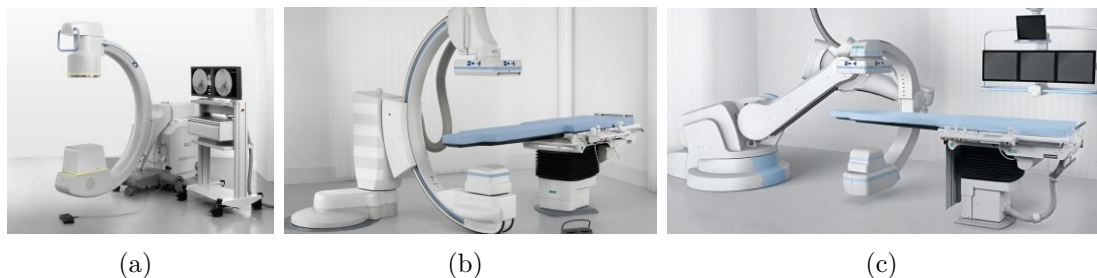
Examples of currently clinically available X-ray devices. (a) Mobile C-arm used in intervention rooms. (b) Robotically controlled C-arm (Siemens Dyna CT) with 3D volume reconstruction capabilities. (c) Latest generation robotically controlled C-arm (Zeego) with two rotation centers for extended field of view 3D Cone-Beam reconstruction. All images are courtesy of Siemens Healthcare.
